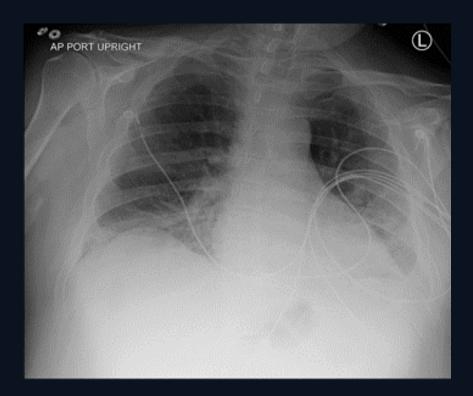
First chest radiograph demonstrates multifocal and bilateral airspace opacities with peripheral and basal predominance. No pneumothorax or subcutaneous emphysema is seen.
